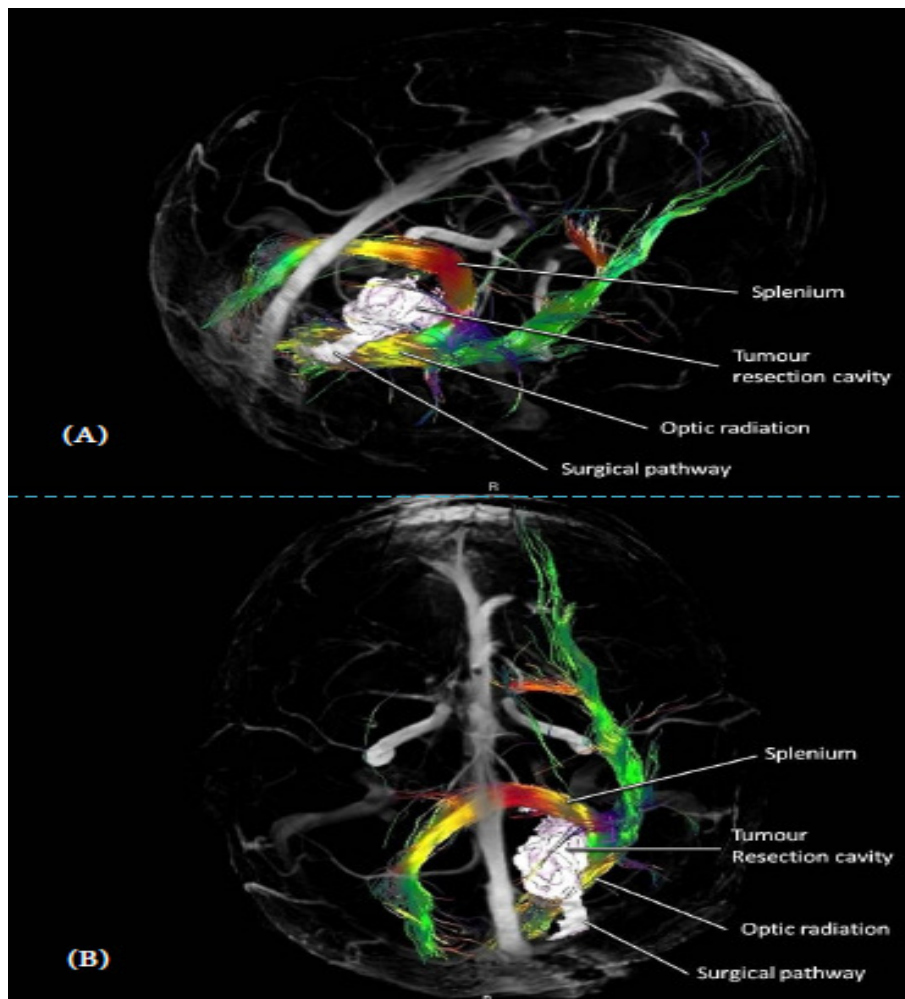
MRI on postoperative day 1 with DTI. (A) Right posterior oblique view. (B) View from the top. The postoperative resection cavity (white) is located just superior to the spared medial sweep of the right optic radiation (green) round the occipital horn to reach the primary visual cortex of the medial occipital lobe. The splenium (red and yellow) is just rostral to the resection cavity. The surgical pathway created by the “Doigt-de-Dieu” (also in white) is shown stretching from the brain surface to the resection cavity above the optic radiation.
